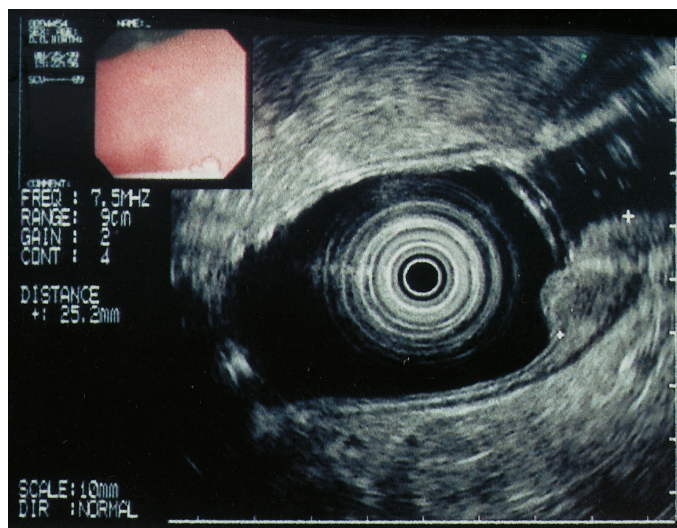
Endoscopic ultrasonography showing a 2.5-cm isoechoic tumor with a central pit. There is blurring mucosal and submucosal layers with some hypoechoic components. The muscularis propria layer is intact.
